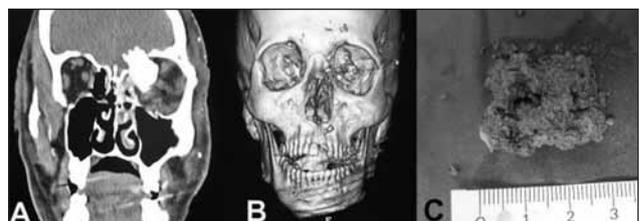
The coronal (A) and 3-dimensional (B) CT scans of the same patient revealed a big foreign body on the anteromedial edge of the orbit. The fragment was composed of mud (C).
